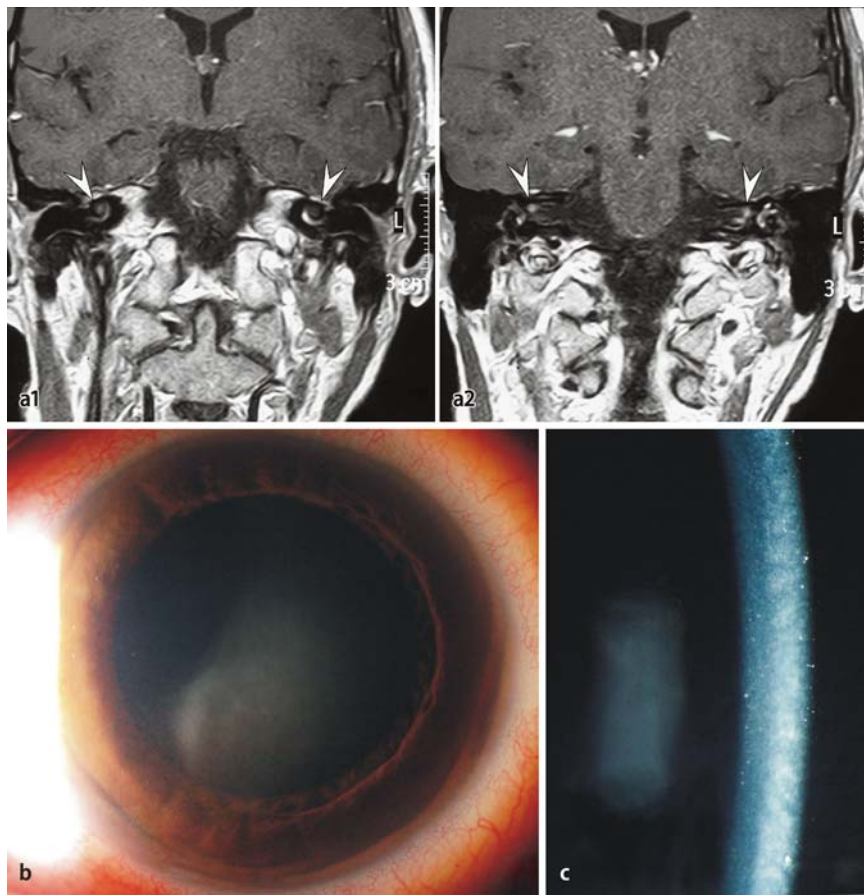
a1, a2 Magnetic resonance imaging of the brain. Coronal T1-weighted image showing contrast enhancement of bilateral cochlea (white arrows, a1) and vestibular nerves (white arrows, a2), predominantly on the left side. Photograph of the left eye demonstrating typical features of interstitial keratitis: b diffuse corneal haze, c central midstromal haze revealed by slit-lamp examination
